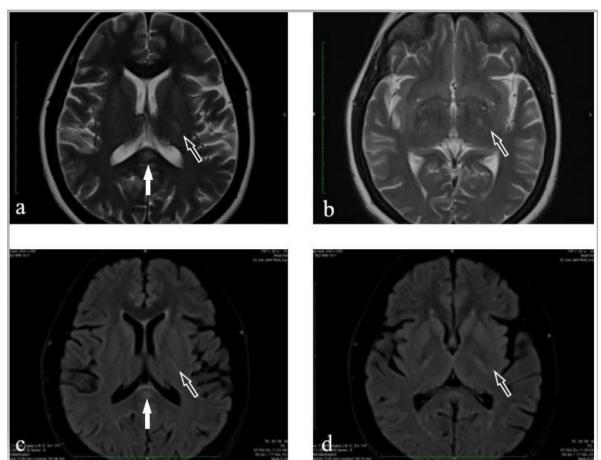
Repeat Magnetic resonance imaging of a patient showing axial sections of T2-weighted (a, c) and fluid attenuated inversion recovery (b, d) images reveals residual T2/FLAIR hyperintensity in splenium of corpus callosum (solid arrow) and bilateral posterior limb of internal capsule (open arrow).
